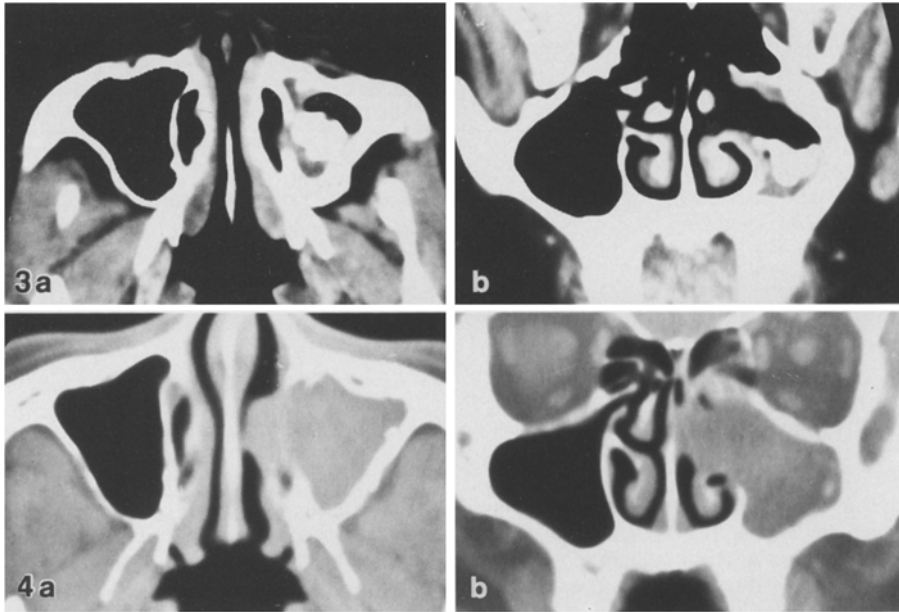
Case 8. A 47-year-old woman with rhinorrhoea for 10 years. Axial (a) and coronal (b) CT shows sclerosis change of the wall of the left maxillary sinus a calcified mass within it
